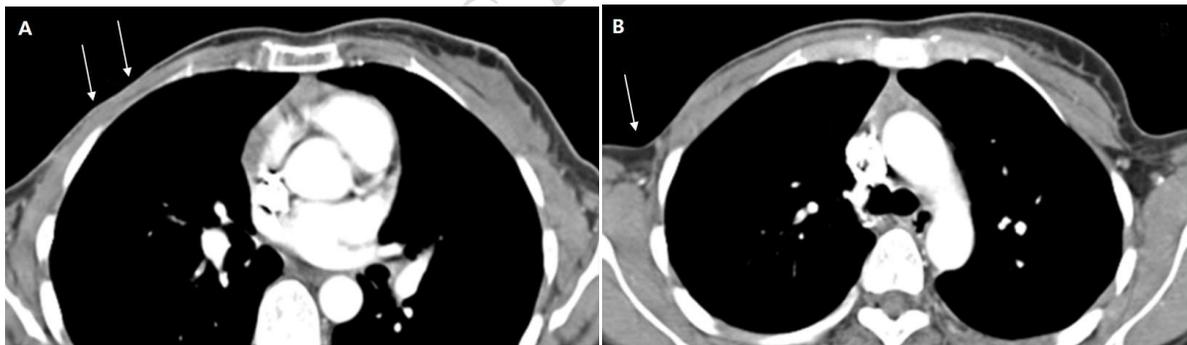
A: Chest CT after modified radical mastectomy demonstrating removal of the right breast tissue, overlying skin and the nipple-areola complex, and remaining underlying pectoralis muscles, resulting in exposure of the bare chest wall (arrows), B: Chest CT showing absence of the right axillary lymph nodes after surgical dissection (arrow)
